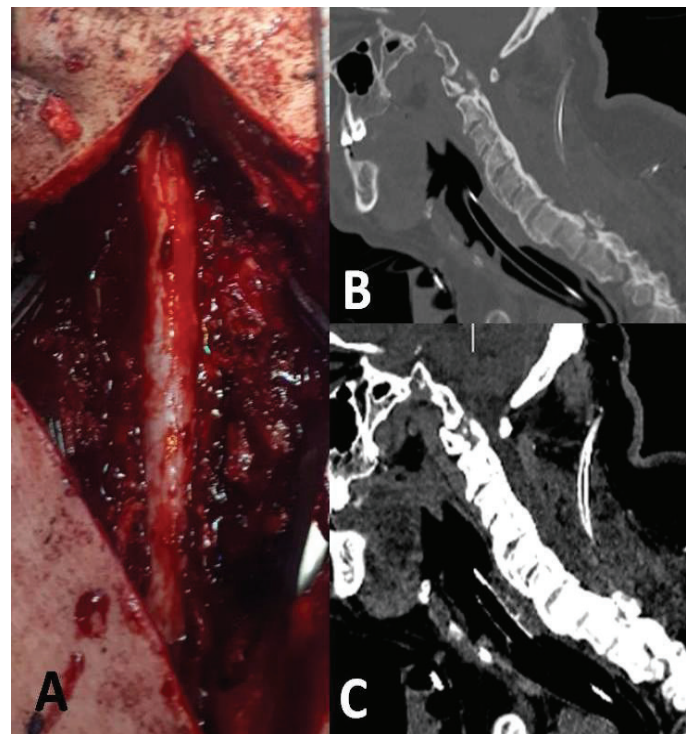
A) Intra-operative view after C2-T2 laminectomy showing the decompression of the spinal cord and bulging of the thecal sac, B) Bone window and C) soft tissue window sagittal cervical CT scan showing the decompression of the cervical spinal canal. The soft tissue window shows haemorrhage, but signs of cord oedema demonstrated increased volume and hypodensity of the spinal cord
